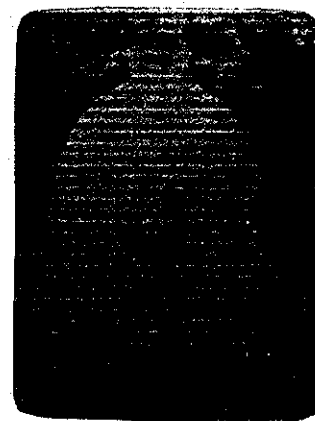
X-ray of a dilated urinary bladder
